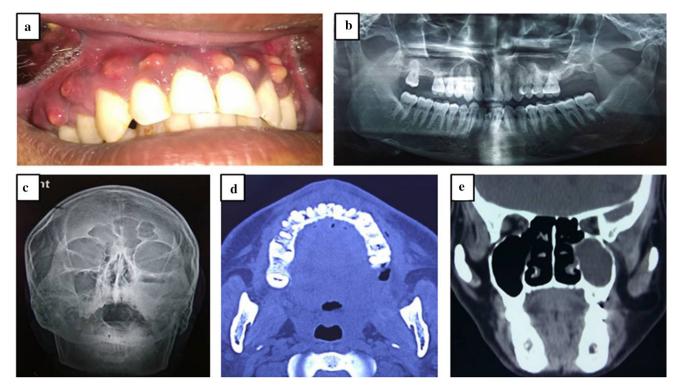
Radiographic investigations. a Typical small abscesses involving whole maxilla. b Orthopantamogram. c Paranasal sinus view. d CT scan (axial view). e CT scan (coronal view)
